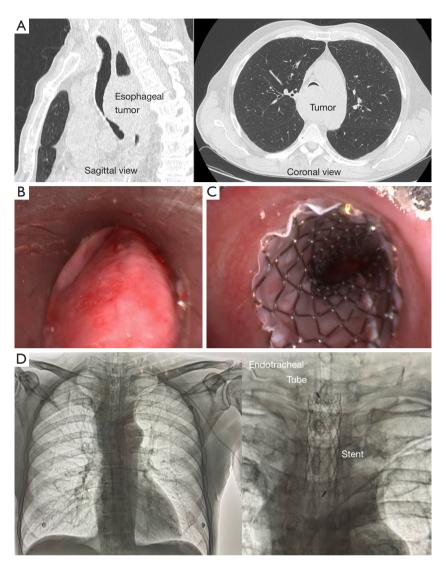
Central airway stenosis before and after stent insertion. Chest computed tomography scan (A) and endoscopy (B) showed malignant stenosis starting in the mid-trachea and extending to the carina. Airway stent reopened the trachea (C). Chest X-Ray confirmed the prompt position of the stent and endotracheal tube (D).
